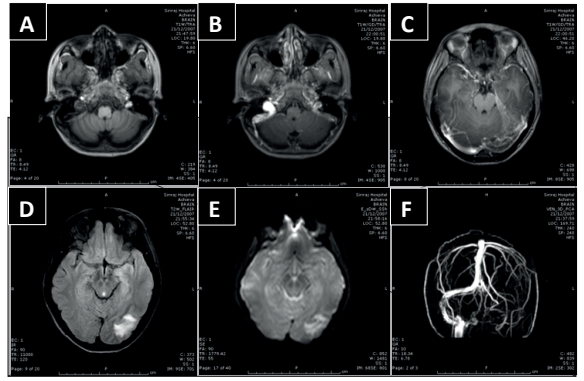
A 19 year-old woman presented with symptoms of severe headache and blurred vision for 5 days. She had been taking oral contraceptive pills for 6 months. Physical examination on admission revealed good consciousness with GCS of 15. CTV brain was performed suspicious of cerebral venous thrombosis, then contrast MRV was done with the result showing long segment of occlusion of left transverse sinus down to left sigmoid sinus and left internal jugular vein on axial T1-weighted image (A), axial T1-weighted image with Gadolinium administration (B,C) and contrast-MRV (F). Axial T2/FLAIR (D) showed increase signal intensity with restrictive diffusion (E) at left temporal region, represented venous infarction. The diagnosis of CVST at left transverse sinus, left sigmoid sinus and left internal jugular vein was confirmed. Pretreatment mRS score = 5, then after anticoagulant therapy, posttreatment mRS score = 0 good outcome.
